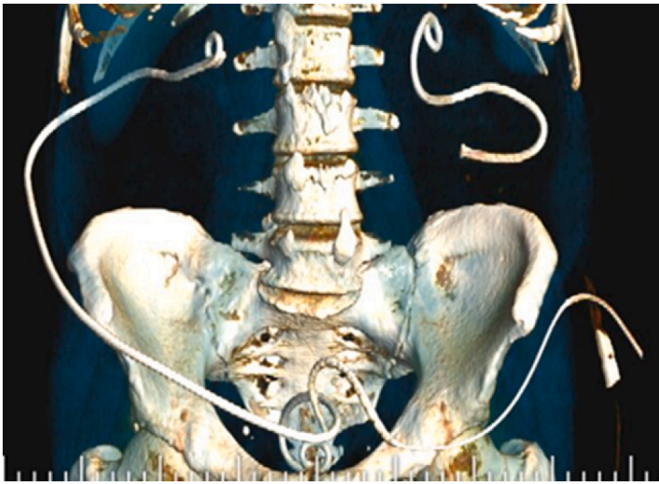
Control CT scan.
